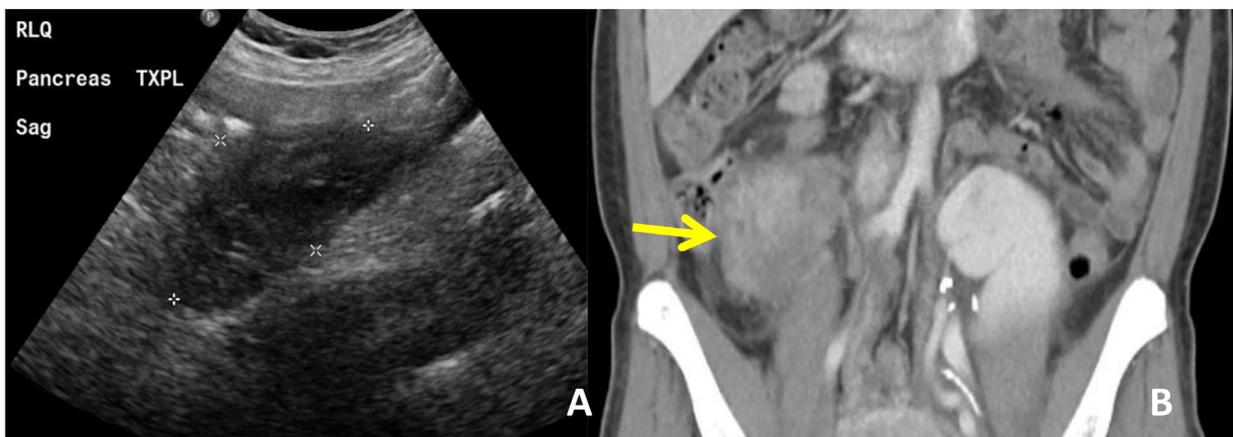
Ultrasound and CT can both be used to demonstrate pancreatic transplant rejection. Image A is the ultrasound of a transplanted pancreas of a 32-year-old female which demonstrates heterogeneous and increased echogenicity compared to the normal appearing graft in Figure 2. Image B is a contrast enhanced CT scan of the lower abdomen of a 37-year-old female showing a transplanted pancreas (arrow) in the right lower quadrant which has heterogeneous enhancement pattern with areas of low attenuation consistent with edema. These imaging findings are seen in the setting of rejection, but are non-specific, and may be seen in other clinical situations, such as graft pancreatitis. Both of these patients underwent percutaneous biopsy demonstrating chronic rejection. (Color version of figure is available online.)
